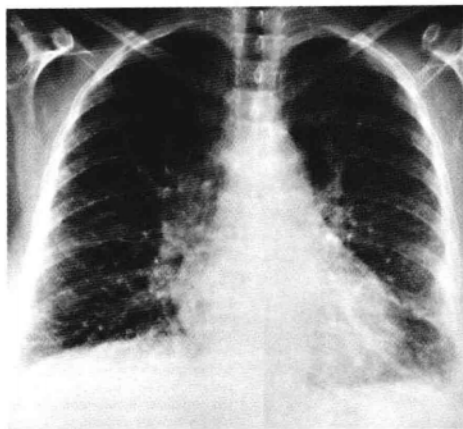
Patient with left ventricular failure. Chest frontal radiograph shows cephalization of pulmonary blood flow.
